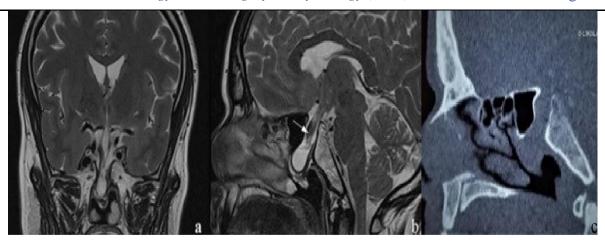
a- coronal section of MRI showing the importance of herniation if the sellar and part of the suprsellar contents .b- on the sagittal section , the abnormal and thickened pituitary stalk is showed by the white arrow .c- the sinus CT showed the bony limits of the defect from the clical recess to the anterior face of the sella.
